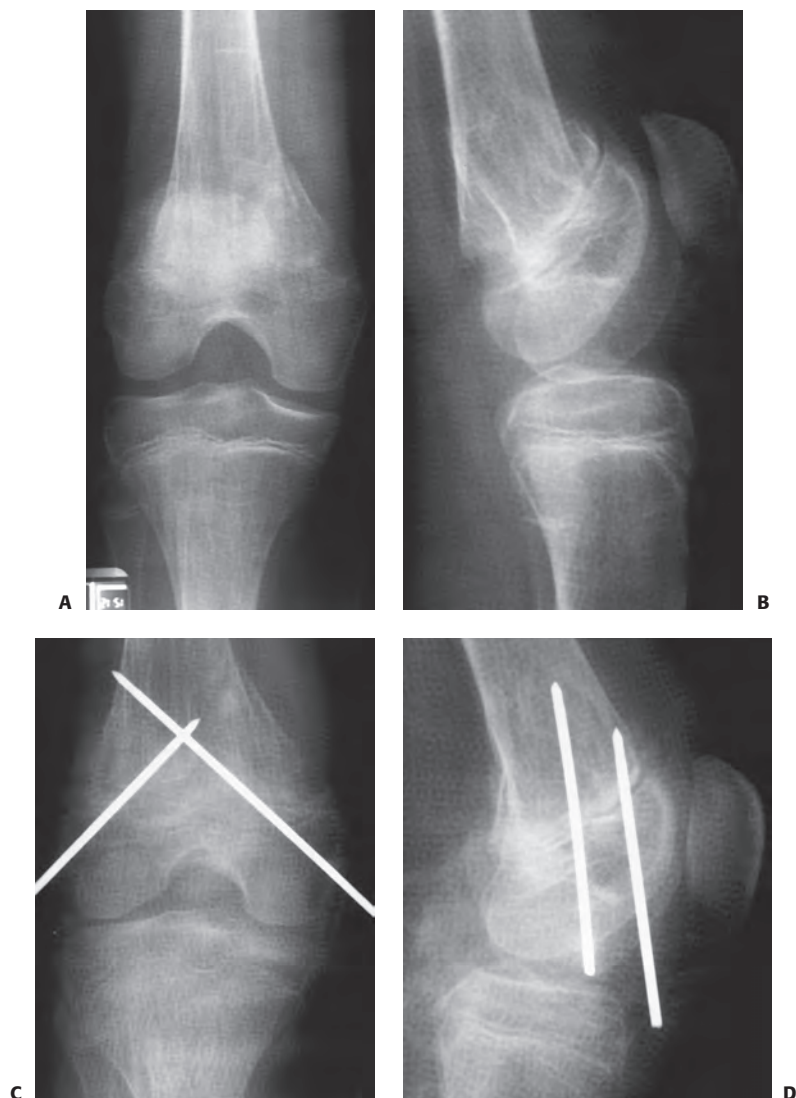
A: Multiple pathologic fractures in a previously healthy teenage boy who developed idiopathic osteoporosis. This anteroposterior radiograph of the right knee and this lateral radiograph (B) demonstrate a displaced distal femoral metaphyseal fracture with apex posterior angulation. C: This was treated with closed reduction and percutaneous pinning and application of a cast. D: This lateral radiograph shows satisfactory alignment with the pins in place.
